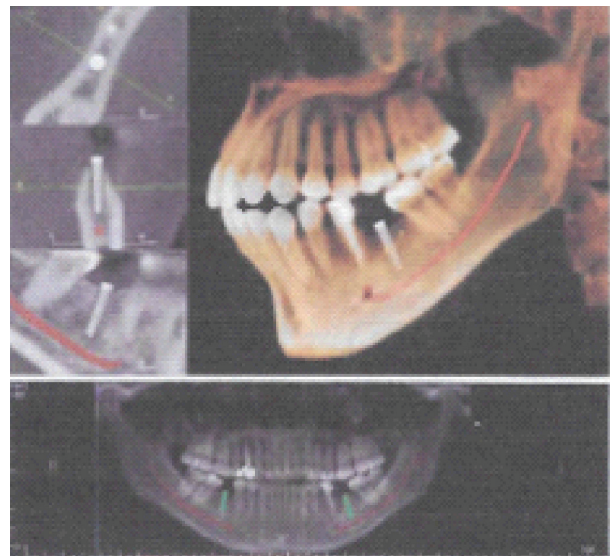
3-D CT used in preparation for implant placement.
